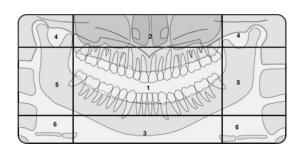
Panoramic radiographs interpretation zone
